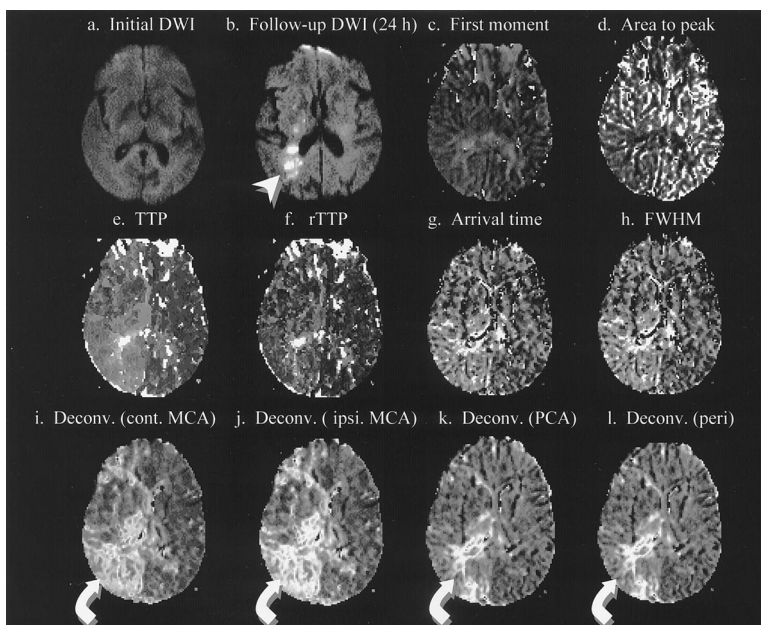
This 80-year-old woman was admitted to hospital for balloon occlusion of a right cavernous carotid aneurysm. The patient remained asymptomatic until she developed a left facial droop during the evening after the procedure. Her initial DWI was negative for an infarct (a). On the follow-up DWI in 24 hours (b), the lesion in the parietooccipital region at the MCA/PCA watershed zone became apparent (arrowhead). PWIs using deconvolution methods (Deconv.; i through l) revealed abnormality involving the right posterior MCA/PCA watershed (curved arrows), whereas the other methods failed to demonstrate an unequivocal area of abnormality (c through h). Note that the extent of abnormality demonstrated on the deconvolution methods differs, depending on the selected AIFs. The image calculated by the AIF from the contralateral MCA (j) overestimates the area of infarction, whereas the images with the AIF from the peri-infarction area (l) showed the closest agreement with the follow-up DWI (b). Abbreviations as in Figure 6.
